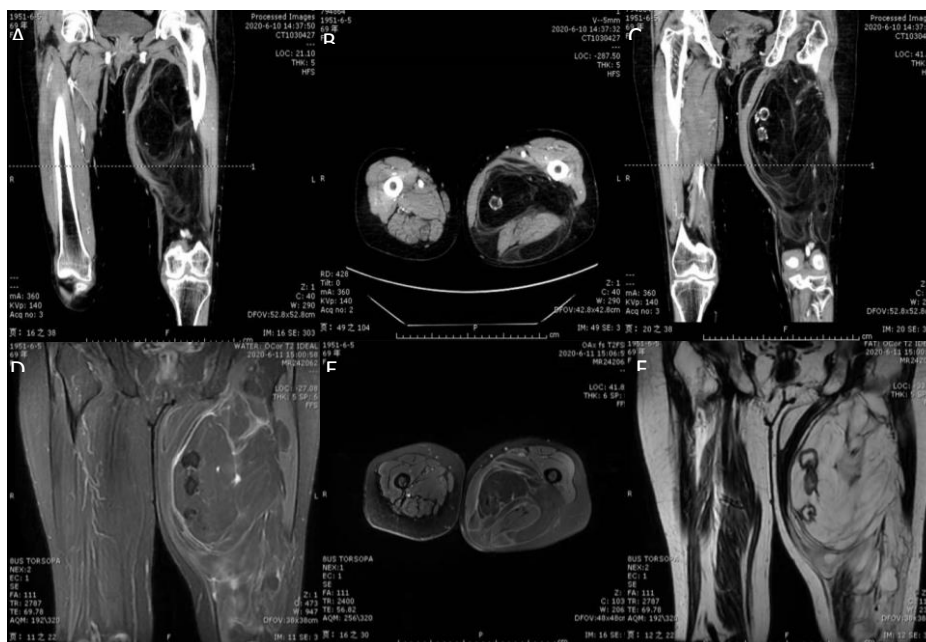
Computed tomography images of case 1A-C: In the left thigh, there was a large fat density mass in the medial and posterior femoral muscle space with irregular shape and unclear boundary. There was strip-like soft tissue density in the mass (dimensions: 29.1 cm×16.1 cm×7.2 cm). Magnetic resonance imaging of case 1D-F: There was a large fat signal mass in the medial posterior femoral muscle space of the left thigh with irregular shape and unclear boundary. There was strip-like soft tissue signals within it (dimensions: 27.8 cm×16.1 cm×6.2 cm)
